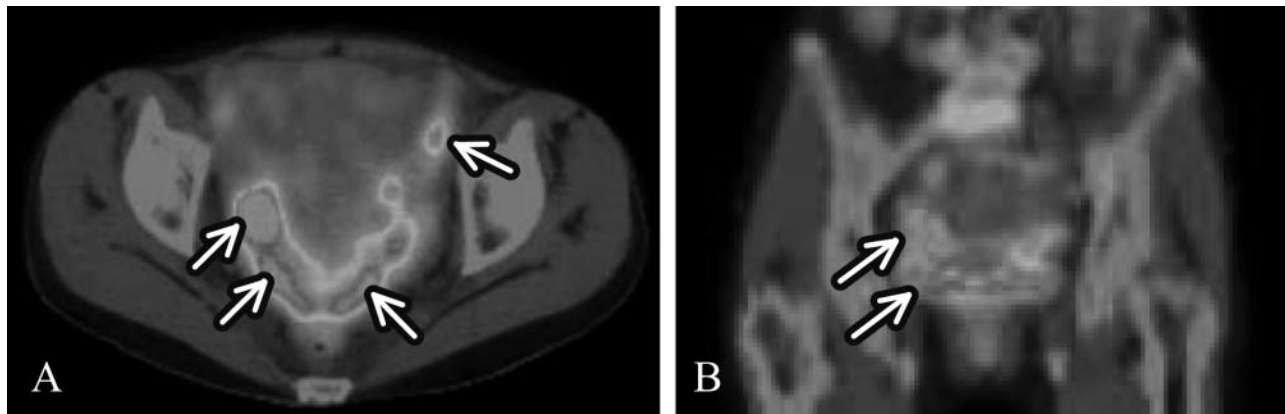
(A) axial FDG-PET/CT showing markedly increased FDG accumulation in the right ovary (arrow) and peritoneum (arrow) and (B) coronal FDG-PET/CT showing the increased metabolic activity in the right ovary (arrow) and peritoneum (arrow).
